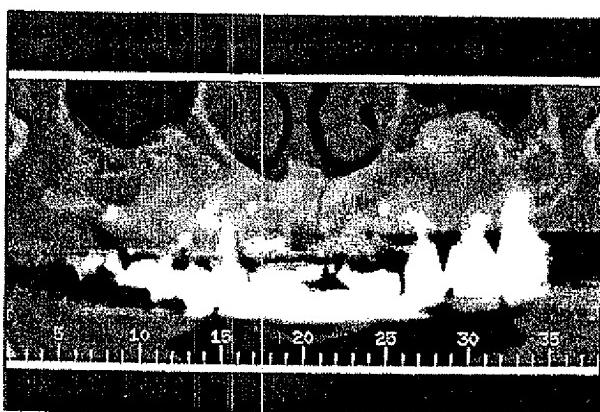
Eight-month postoperative panoramic radiograph of connective tissue healing.
